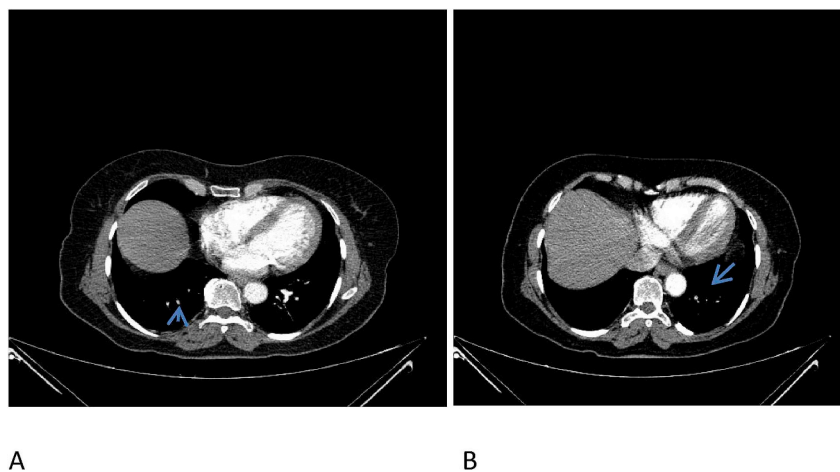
67-year-old woman with 1 months of dry cough at night and varicose veins in legs. CT pulmonary angiography shows pulmonary emboli with obliteration in bilateral lower lobe artery (arrows in A and B).
